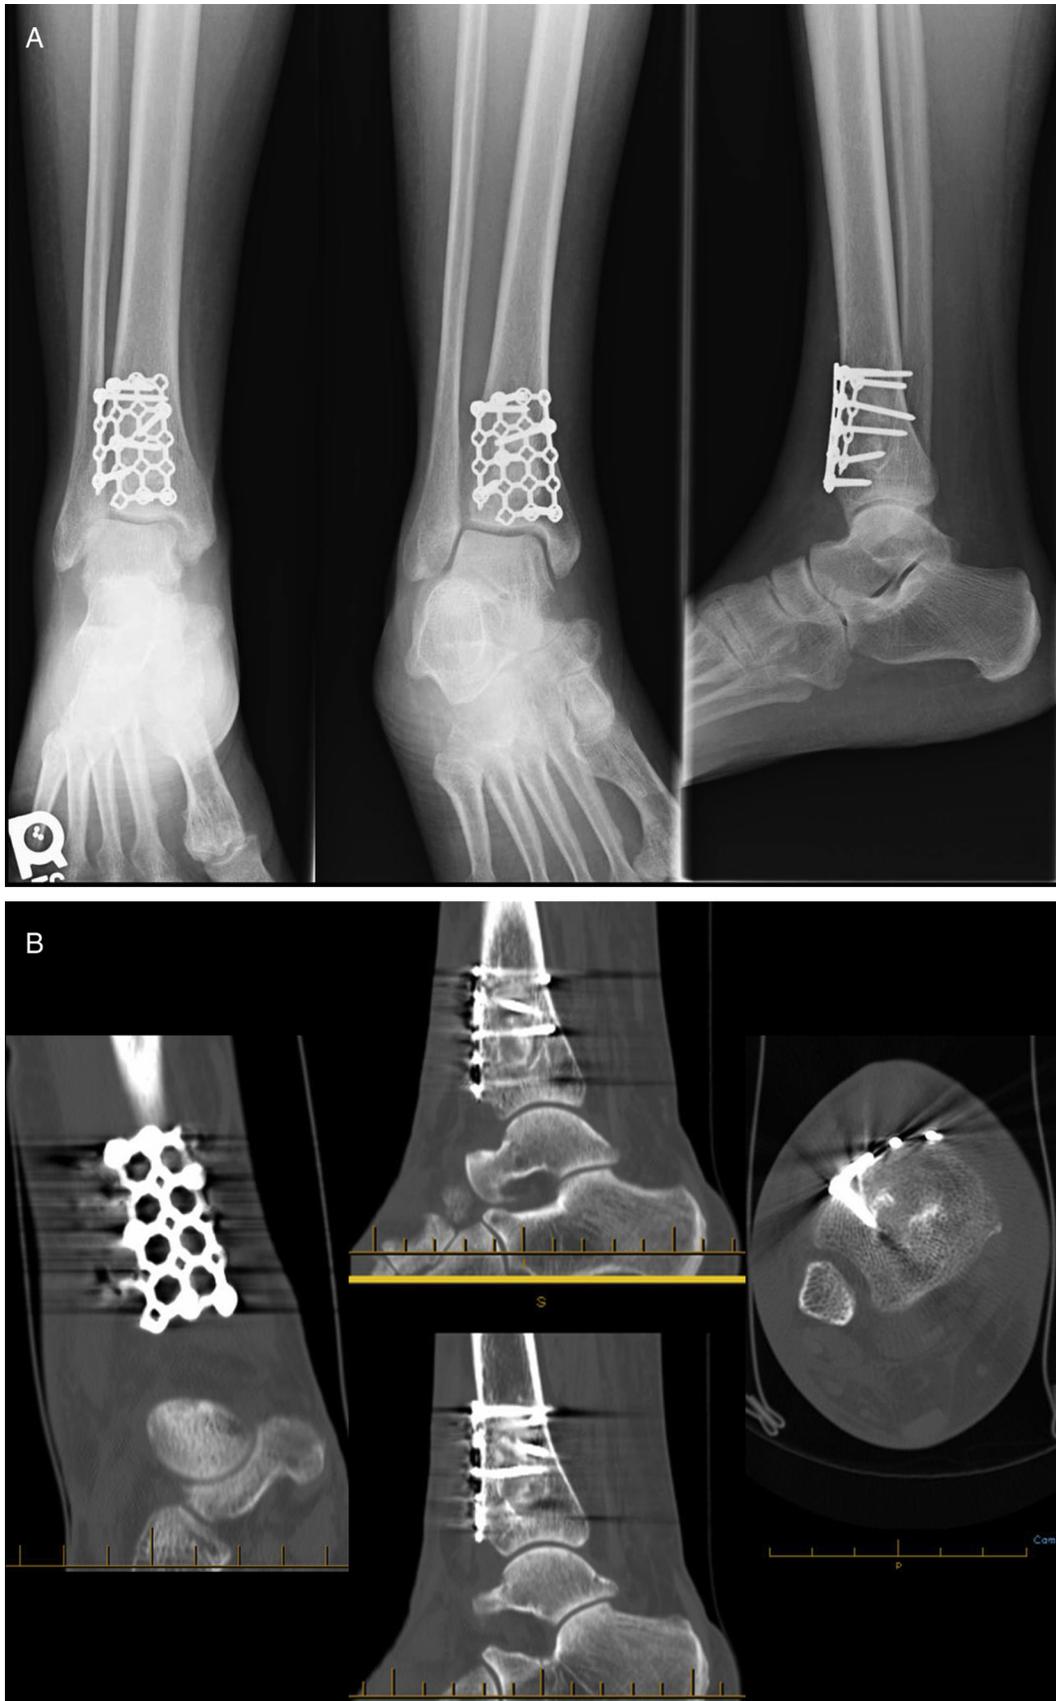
Radiographs (A) and computed tomography images (B) at 9 weeks postoperatively showing the hardware in good alignment, with no residual avascular necrosis. Incorporation of the bone substitutes into native bone can also be observed.
